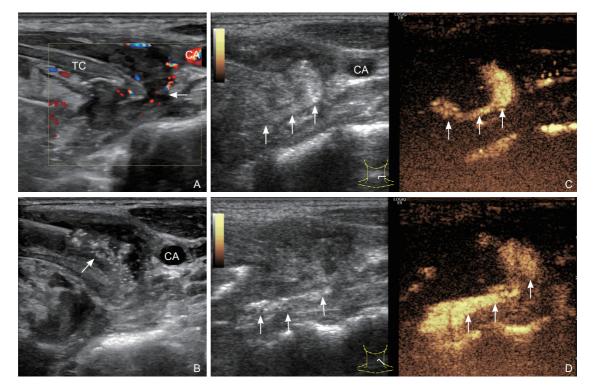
(A) The transverse image showing an abscess emerging from the posterolateral aspect of the thyroid cartilage (TC), which indicated that the abscess started from the pyriform sinus; (B) Injection of ultrasound contrast agent into the abscess. The images showing the fistula (C and D). TC, Thyroid cartilage; CA, Common carotid artery.
